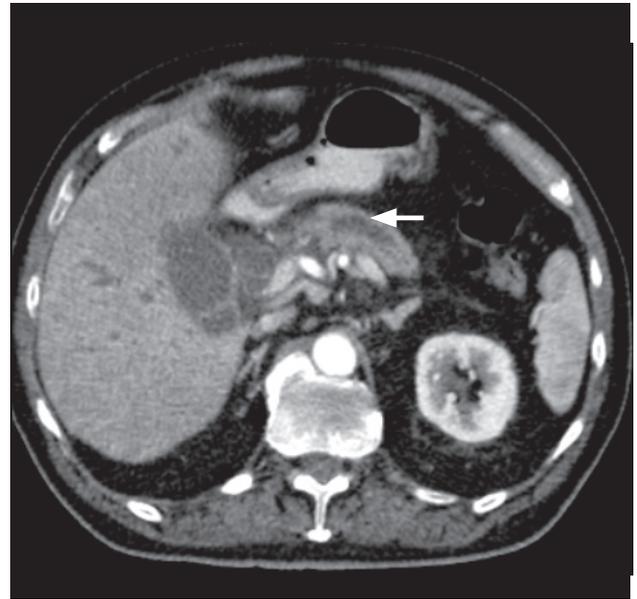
Axial enhanced CT image of the abdomen shows the dilated pancreatic duct (arrow).
